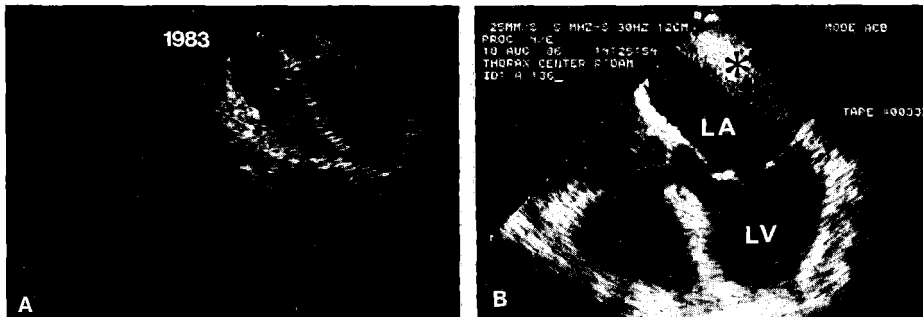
A, Transesophageal two-dimensional echocardiogram showing a cardiac four-chamber view obtained in a healthy volunteer in 1983, obtained with the 32 elements 3.5 MHz prototype transducer. B, A cardiac four-chamber view obtained in 1985 in a patient with mitral stenosis and extensive thrombus formation (asterisk) in the left atrium, obtained with the 64 elements 5.6 MHz prototype transducer. Note the difference in image quality between Figs. 1B, 2A and 2B. LA = left atrium; LV = left ventricle.
